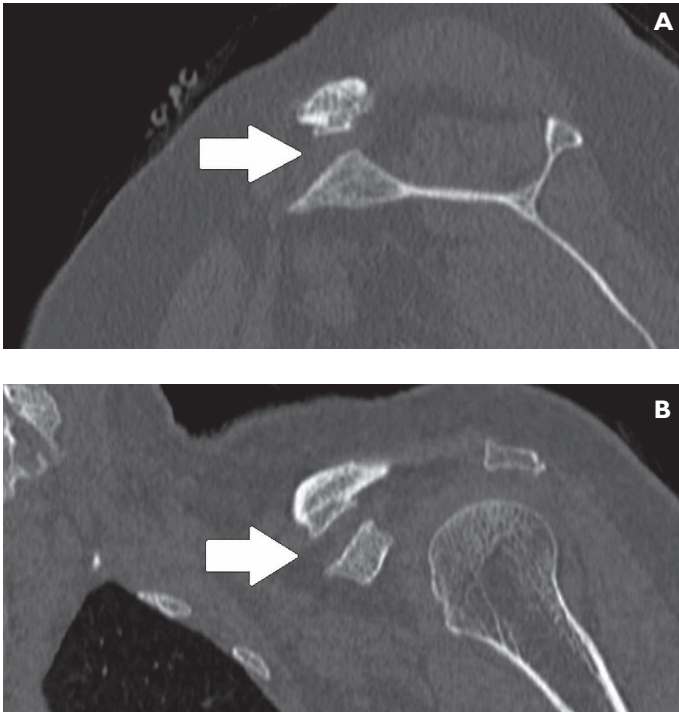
Computed tomography scan bone window of the left shoulder in the sagittal section (A), and in the coronal section (B), demonstrating arthrosis of the coracoclavicular joint (white arrow).
